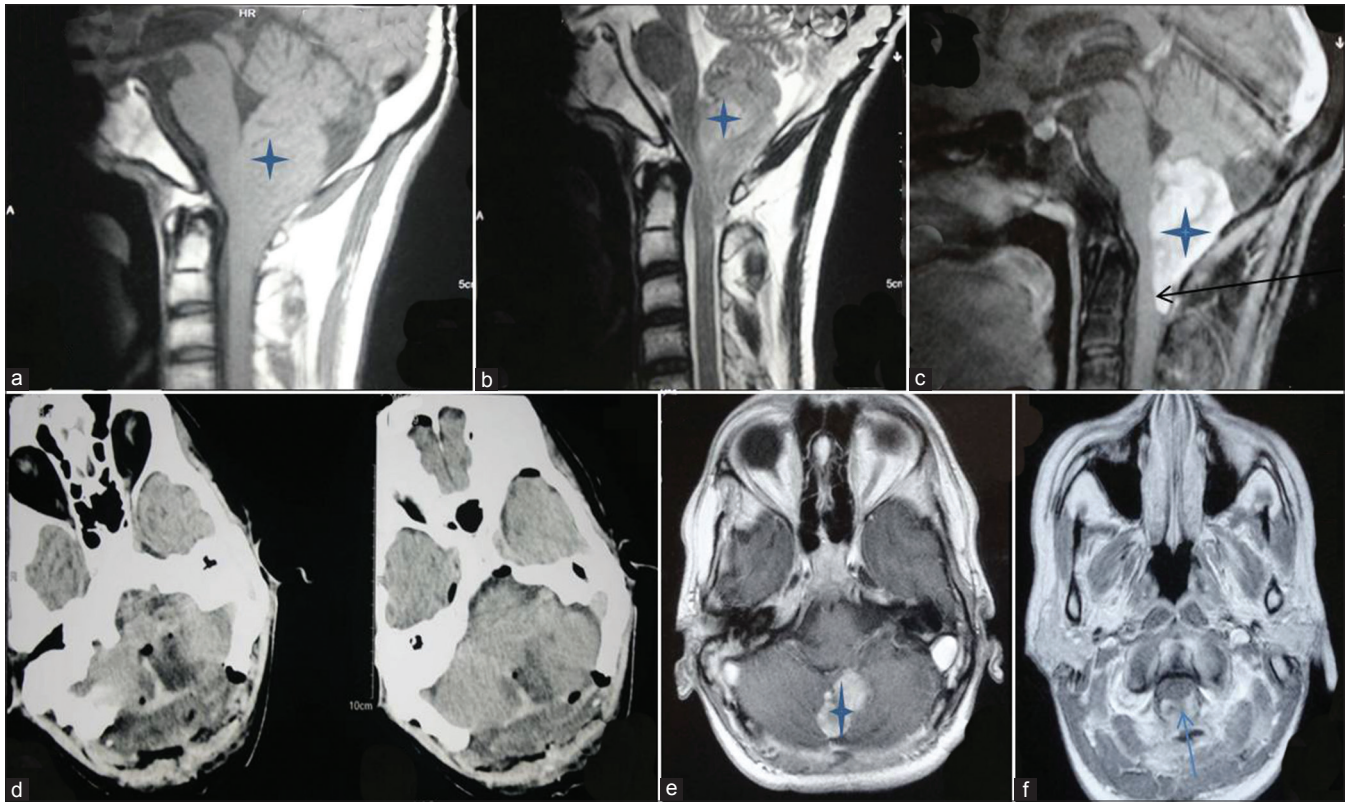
(a-c) Pre-operative magnetic resonance imaging showing the lesion (star) as isointense on T1-weighted and T2-weighted with contrast enhancement respectively. (c) Lesion extending into the upper cervical cord (arrow), (d) Immediate post-operative computed tomography scan magnetic resonance imaging performed 6 months after surgery showing the residual tumor in the (e) Cerebellum (star) and the (f) Upper cervical cord region (arrow)
